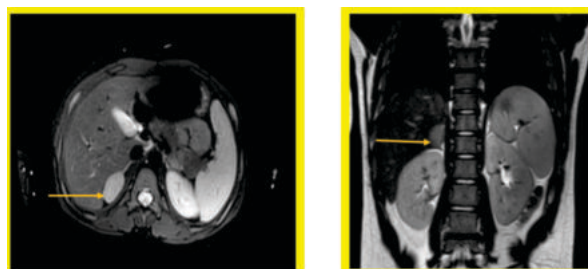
MRI – right adrenal adenoma
